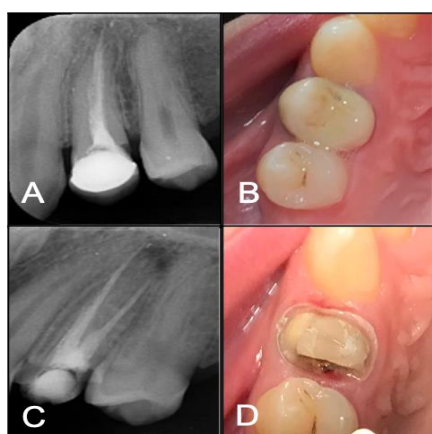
#24 (A) Preoperative periapical radiograph; (B) Preoperative clinical photograph; (C) Preoperative distal angulated radiograph; (D) Clinical photograph after crown removal.
